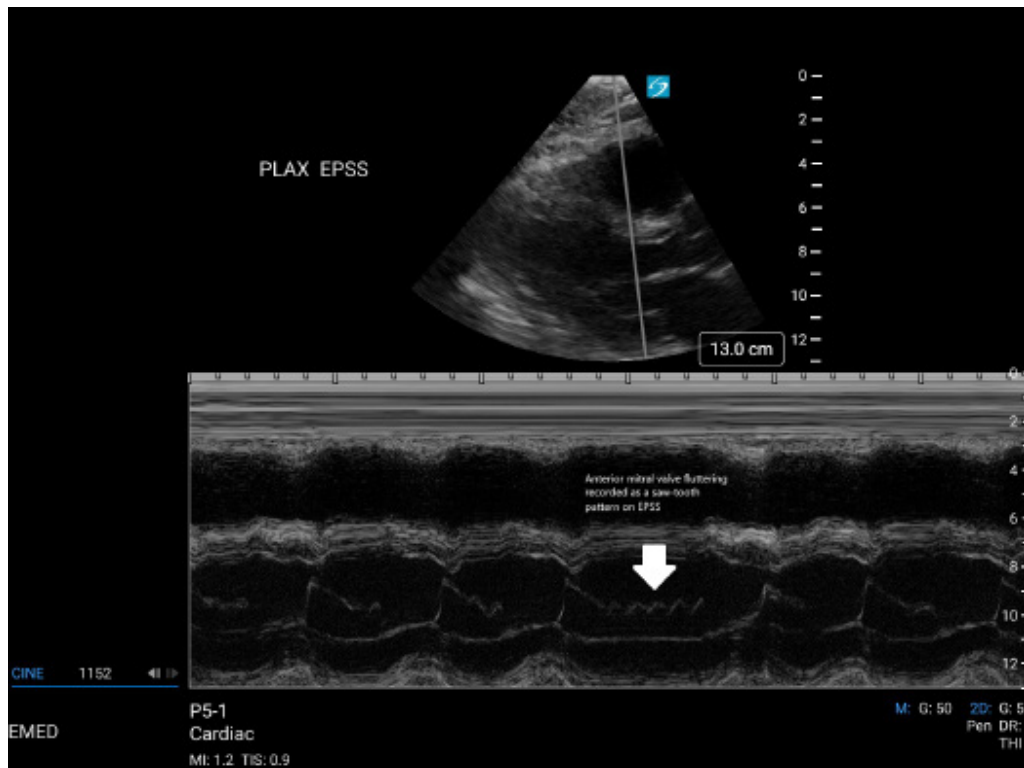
M-mode visualization of anterior mitral valve fluttering in parasternal long axis shows a sawtooth pattern (arrow). PLAX EPSS, E-point septal separation measured in the parasternal long-axis view.
